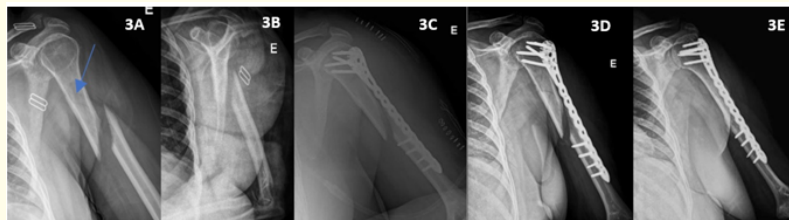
Non-acceptable fracture reduction. The blue arrow shows an undisplaced secondary line of fracture that extends almost to the surgical neck. The third image is the pos-operative x-ray and the fourth at 1 month of follow-up. The final x-ray is 4 months after surgery. Consolidation was obtained.
